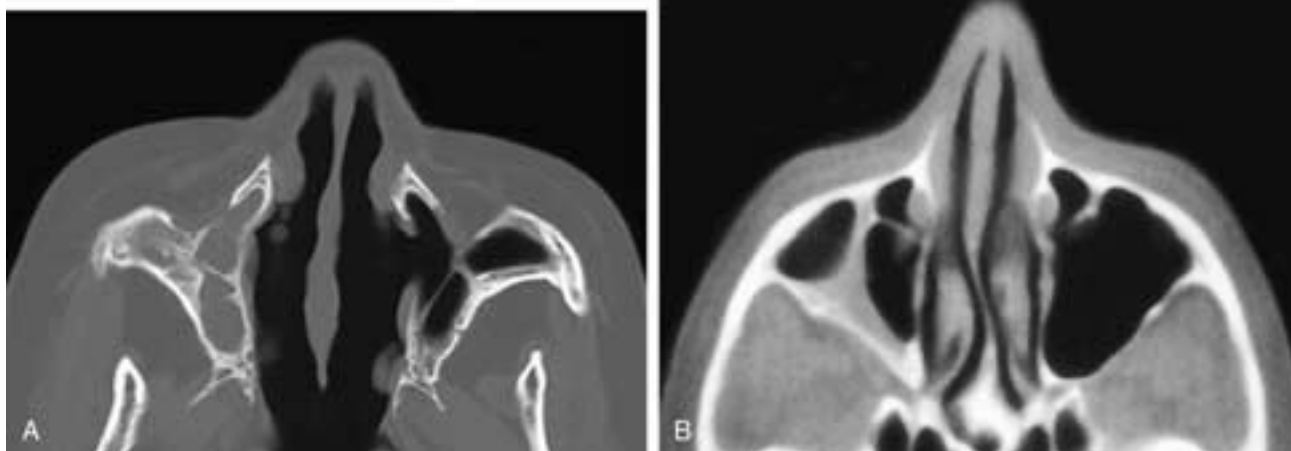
Axial CT scan (A) on a patient who has had bilateral Caldwell-Luc procedures. On the right side, the defect is fibrosed over and the sinus cavity is opacified. On the left side, fibrous strands extend from the surgical defect to the posterior sinus wall. Axial CT scan (B) on a patient after a right Caldwell-Luc procedure. On this more cranial scan through the antrum, a septum has formed between the anterior and posterior sinus walls. If this septum completely obstructs the lateral portion of the sinus, a postoperative mucocele will develop.
